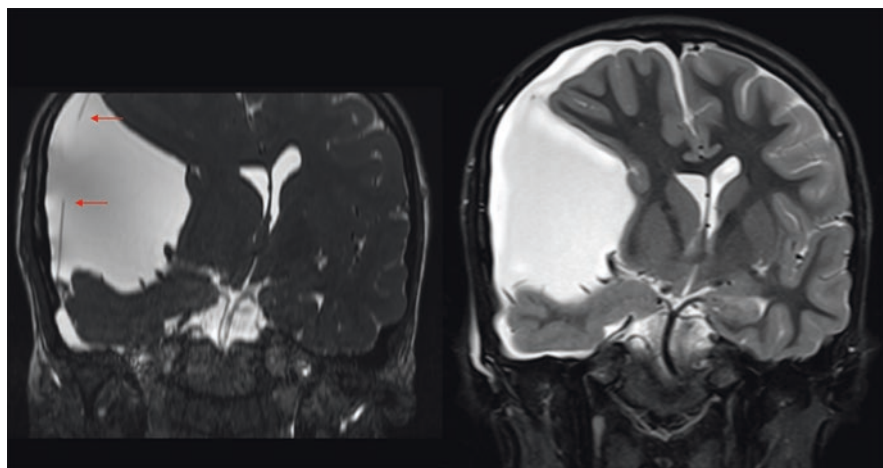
Coronal view of a Galassi type III AC on CISS (left) and T2 (right)-weighted MR images. The cyst membrane has ruptured with concomitant subdural hygroma. The fine cyst wall with the site of rupture (arrow) can only be seen on CISS sequences
